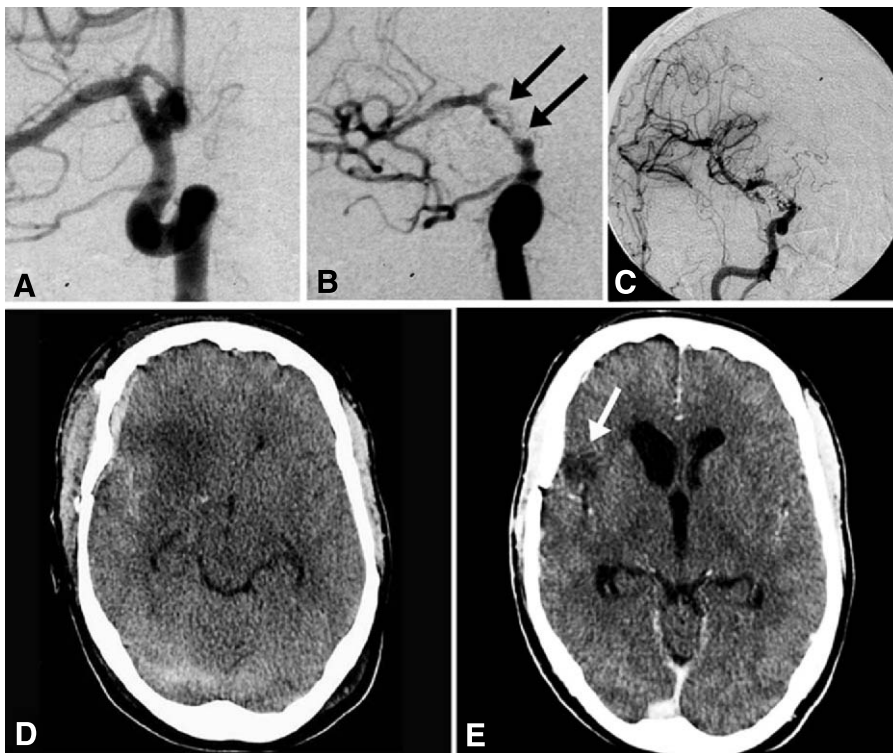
Case 3 Angiography showing the blister-like ICA aneurysm (A) and the narrowing of the ICA segment due to the clip application (*double arrow*) during first papaverine application (B). (C) Angiography with functioning EC-IC bypass. CT scan just before the first papaverine application with hypodensity in the right basal ganglia (D) and after 3 months (E) showing a small infarction in the right fronto-opercular region (*arrow*)
